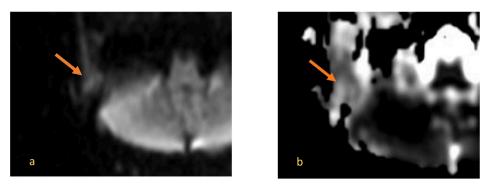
DWI (a) and ADC map (b). Arrows showing restricted diffusion in EAC mass.
